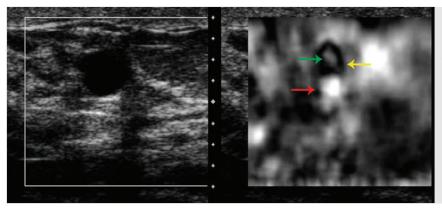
On some systems an artifact, the bull's eye artifact, is identified with benign simple and complicated cysts. This artifact is characterized with the cyst black (*yellow arrows*) with a bright central spot (*green arrow*) and a bright spot behind the cyst (*red arrow*). This artifact has been shown to have a very high sensitivity and specificity for characterization of benign cystic lesions. (Reproduced with permission from Barr RG, Lackey AE. The utility of the "bull's-eye" artifact on breast elasticity imaging in reducing breast lesion biopsy rate. Ultrasound Q 2011; 27(3):151–155.)
